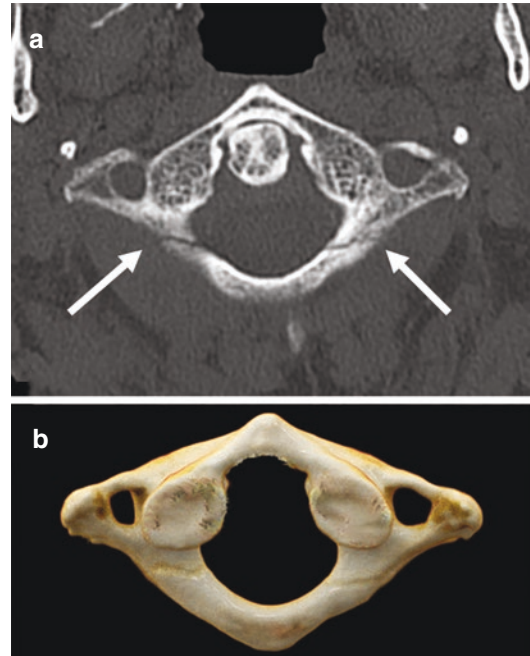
An 88-year-old man was admitted to the Emergency Department after a head blunt trauma due to a car collision. Axial CT (a) and image 3D reconstruction (b) show linear fracture (arrows) of the posterior arc of the atlas (type I both sec. Landels and sec. Levin and Edwards)
